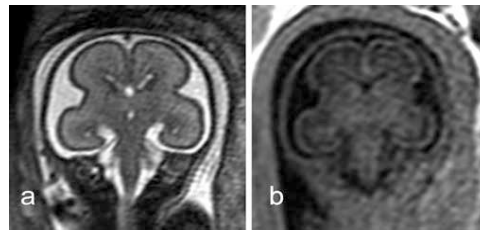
fetal brain in (a) T2-w and (b) T1-w MRI
